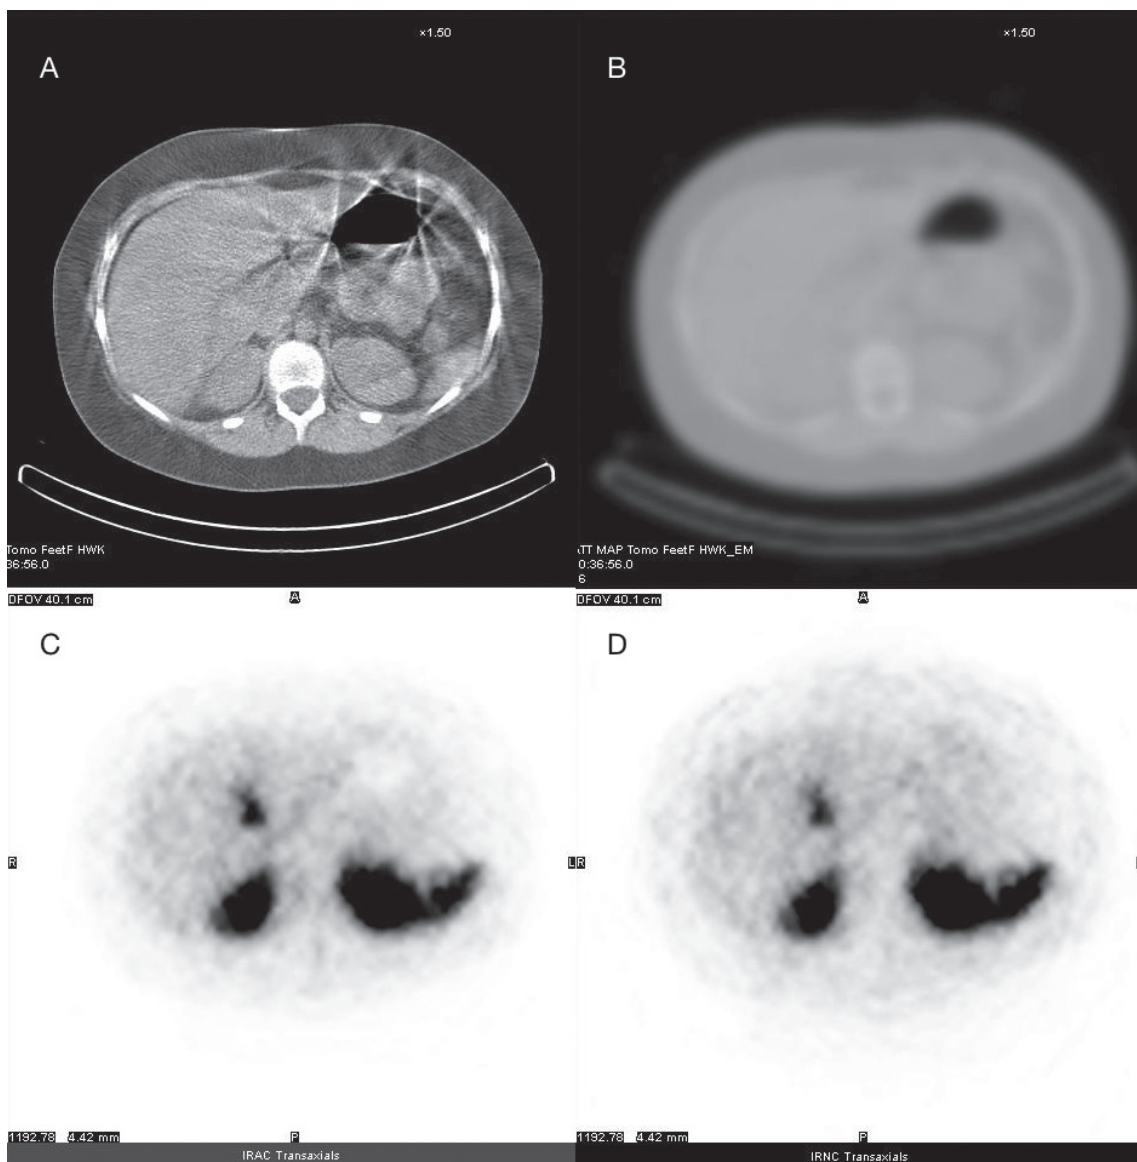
(A) Transaxial CT data from a slow rotation CT scan of the abdomen showing an air pocket in the gastrointestinal tract and (B) corresponding CT attenuation map clearly showing the air pocket. (C) The AC SPECT slice clearly shows the air pocket indicating that the erroneous presence of the air pocket in the image is due to the AC process. (D) The corresponding uncorrected SPECT slice shows the absence of the air pocket indicating that the air pocket had transitioned between the acquisition of the CT and SPECT data.
